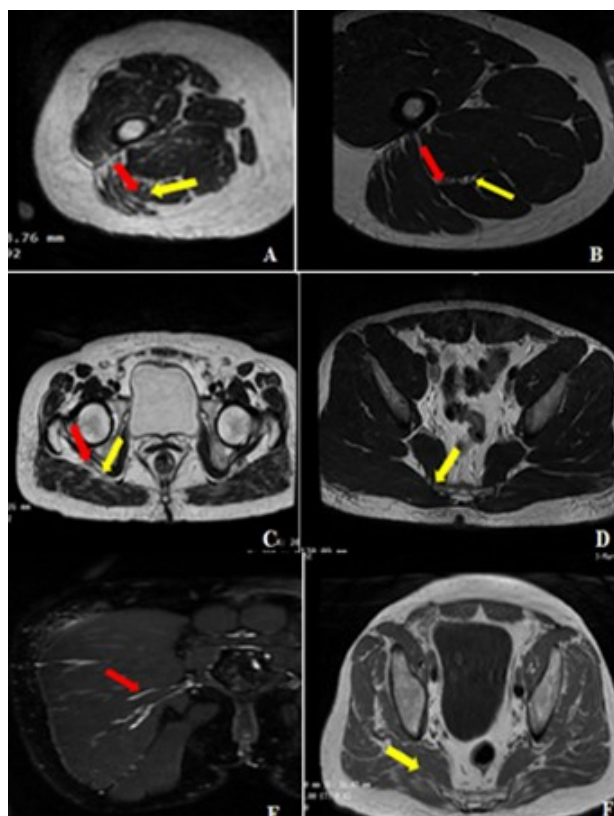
Axial T2- weighted MRI images demonstrating levels of sciatic nerve bifurcation (A-C) at the upper border of popliteal fossa (A), upper thigh (B), subgluteal region(C). The red arrows represent the common peroneal nerve while the yellow arrow demonstrates the tibial nerve. Anatomical variation of Piriformis muscle (D-F): variation I (D) with typical pear-shaped morphology (yellow arrow). Variation II (E) in which the piriformis is divided into two parts with the common fibular nerve (red arrow) coursing between them. Variation III (F) demonstrates the union of the piriformis muscle with the gluteus medius muscle (yellow arrow).
